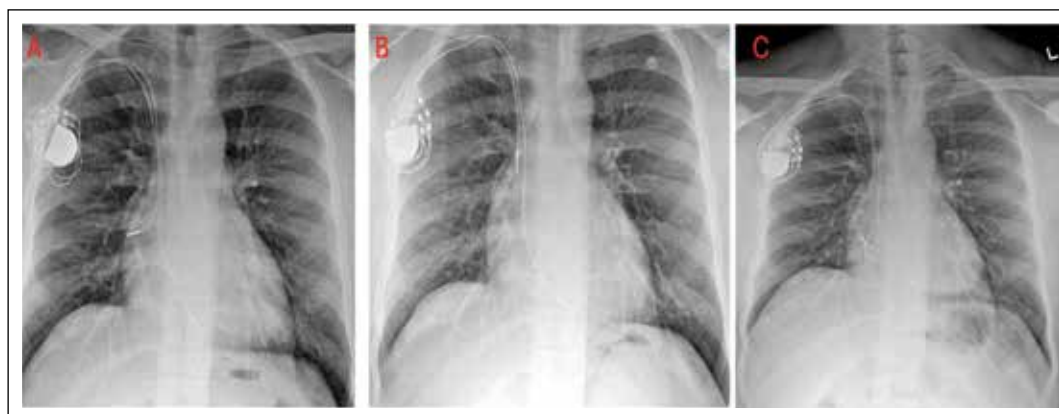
These are the series of frontal chest radiographs of the patient who received dual chamber implantation for symptomatic sick sinus syndrome; during initial implantation, as one can note, the loop of both leads was less seen in the pre-discharge radiograph (A). The device interrogations during follow-up revealed elevated capture thresholds with displacement of the leads along with rotation of the pulse generator. Later, it was successfully repositioned with optimum loops of both leads (C)
